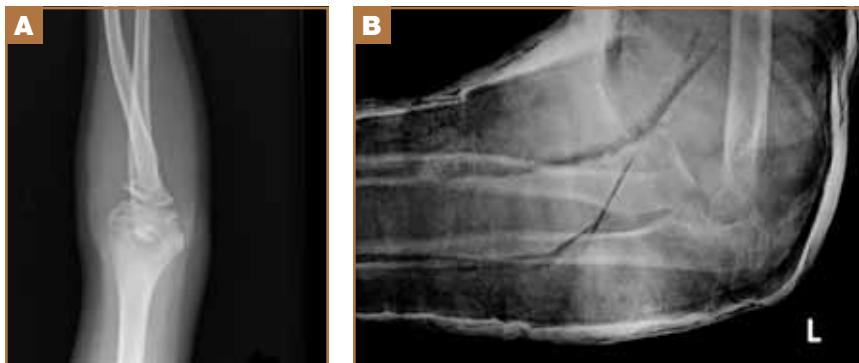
Anteroposterior (A) and lateral (B) radiographic images taken in emergency department show displaced Salter-Harris type II fracture of left radial neck.
